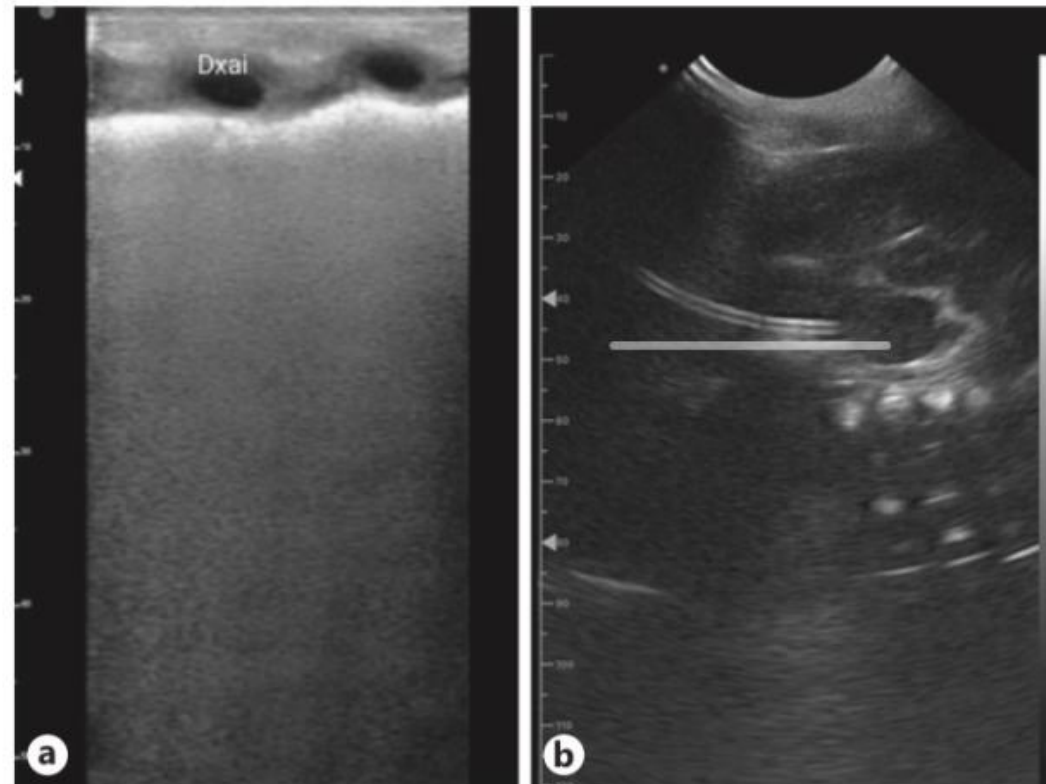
a Image of white lung in the isolated preterm infant. b Ultrasound scan of the correct UVC tip position at the junction of the IVC-RA. IVC, inferior vena cava; RA, right atrium.
